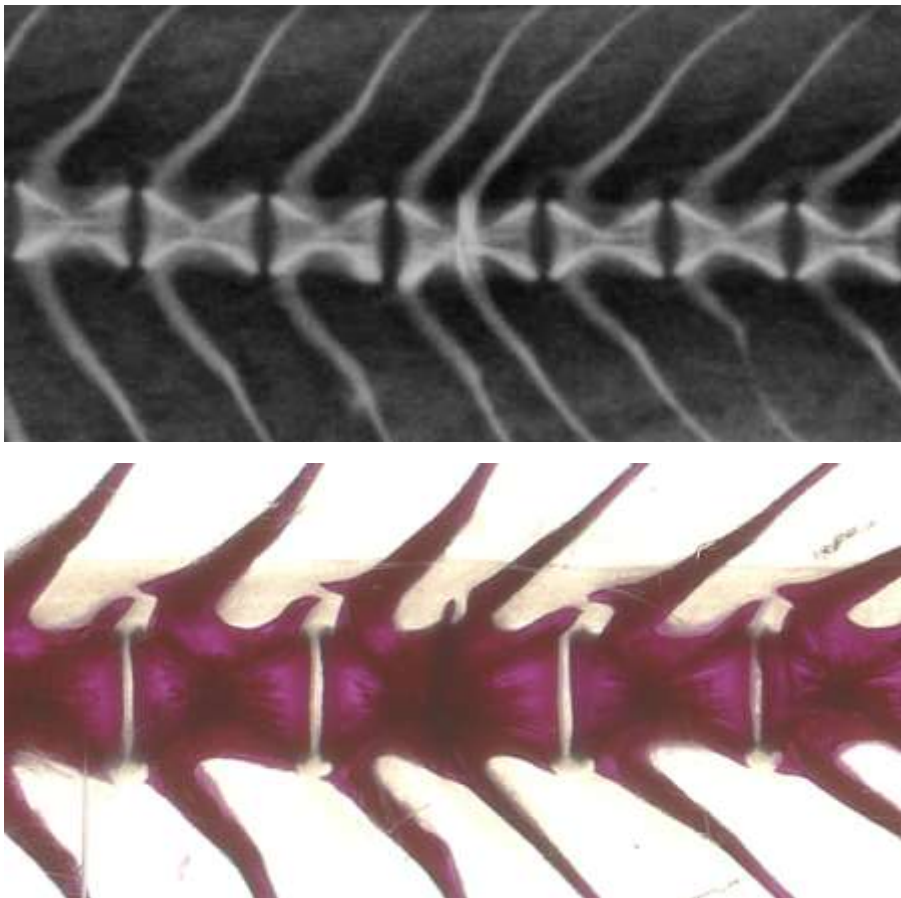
A well organized fusion in two cod vertebrae shown by radiography and in an Alizarin red coloured spine.
